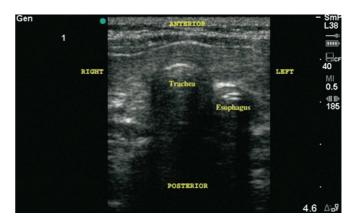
Esophageal intubation. From Figure 2 of Werner SL, Smith CE, Goldstein JR, Jones RA, Cydulka RK. Pilot study to evaluate the accuracy of ultrasonography in confirming endotracheal tube placement. *Ann Emerg Med.* 2007;49(1):75–80.
